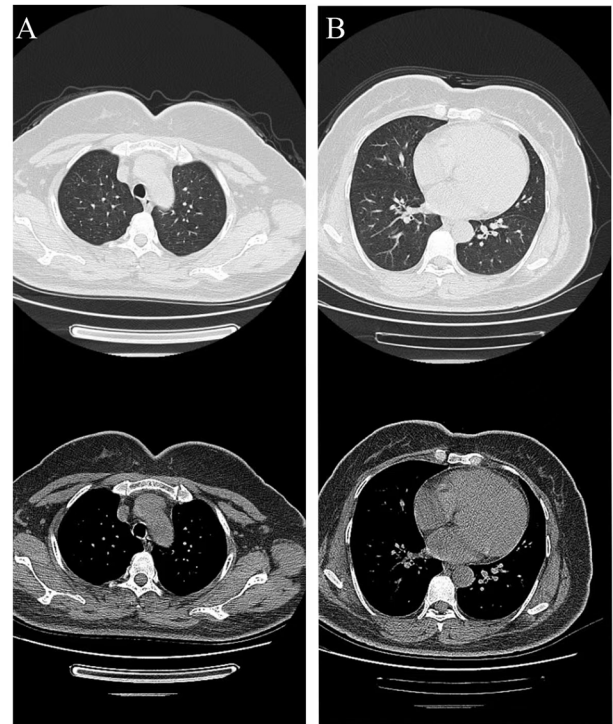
Follow-up chest CT images from November 2023, 1 month following admission. (A) Lung and mediastinal windows of the upper lung lobes. (B) Lung and mediastinal windows of the lower lung lobes. The patchy/nodular opacities observed in Fig. 1 were completely resolved.
